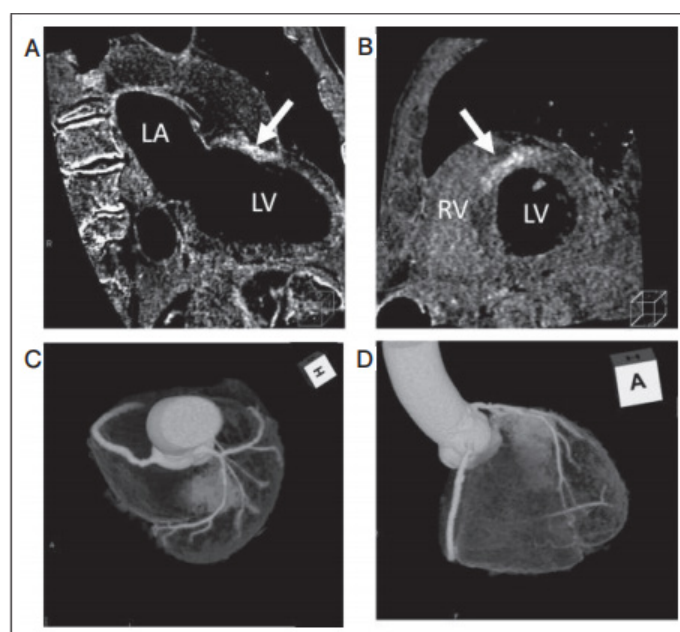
Cardiac CT: Late iodine enhancement (LIE) was observed in the left ventricular basal anterior septum. (A) Long axis; (B) Short axis showing LIE indicated by the arrow. Delayed enhancement is prominently observed on the ventricular septal side, suggesting the potential need for an approach from the right ventricular outflow tract; (C) Superior view of the 3D image of cardiac CT; (D) Right anterior oblique (RAO) view. LIE was observed in the left ventricular basal anterior septum.
